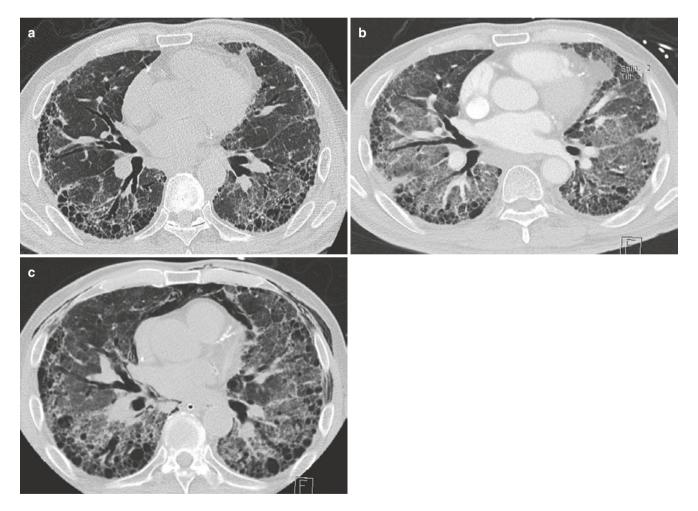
Acute exacerbation of IPF. (a) "Typical" UIP pattern on baseline HRCT. (b) CT image during presentation with worsening dyspnea. (c) Further worsening of the lung with barotrauma resulting in pneumomediastinum and chest wall emphysema
